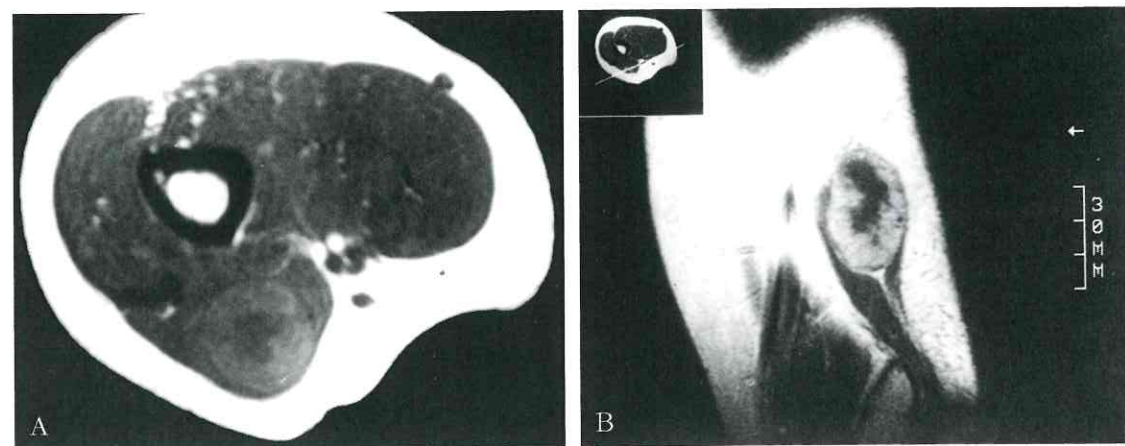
MRI axial (A) and coronal (B) views. T1-weighted image showed a dyshomogeneous lesion arising from the ulnar nerve (A) with peripheral enhancement (B).
